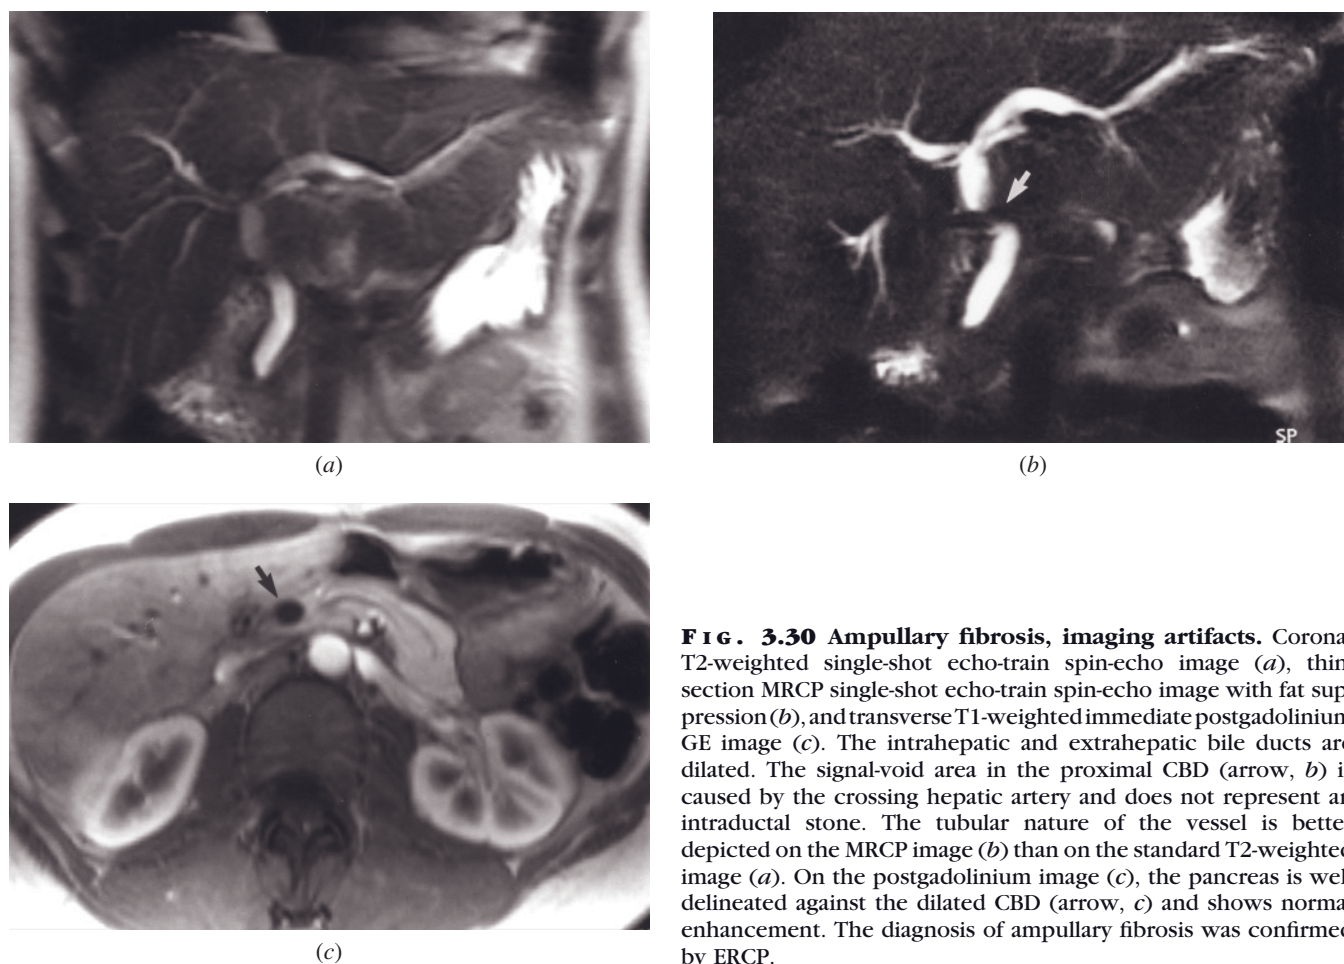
Ampullary fibrosis, imaging artifacts. Coronal T2-weighted single-shot echo-train spin-echo image (a), thin-section MRCP single-shot echo-train spin-echo image with fat suppression (b), and transverse T1-weighted immediate postgadolinium GE image (c). The intrahepatic and extrahepatic bile ducts are dilated. The signal-void area in the proximal CBD (arrow, b) is caused by the crossing hepatic artery and does not represent an intraductal stone. The tubular nature of the vessel is better depicted on the MRCP image (b) than on the standard T2-weighted image (a). On the postgadolinium image (c), the pancreas is well delineated against the dilated CBD (arrow, c) and shows normal enhancement. The diagnosis of ampullary fibrosis was confirmed by ERCP.
